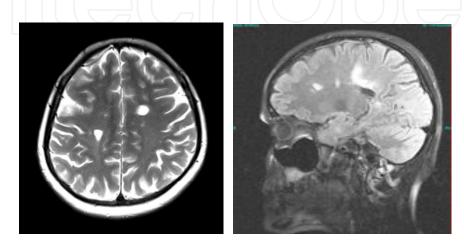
The hyperintense lesion on T2-and FLAIR weighted images. Corpus callosum involvement is noted on the sagittal T2WI.
